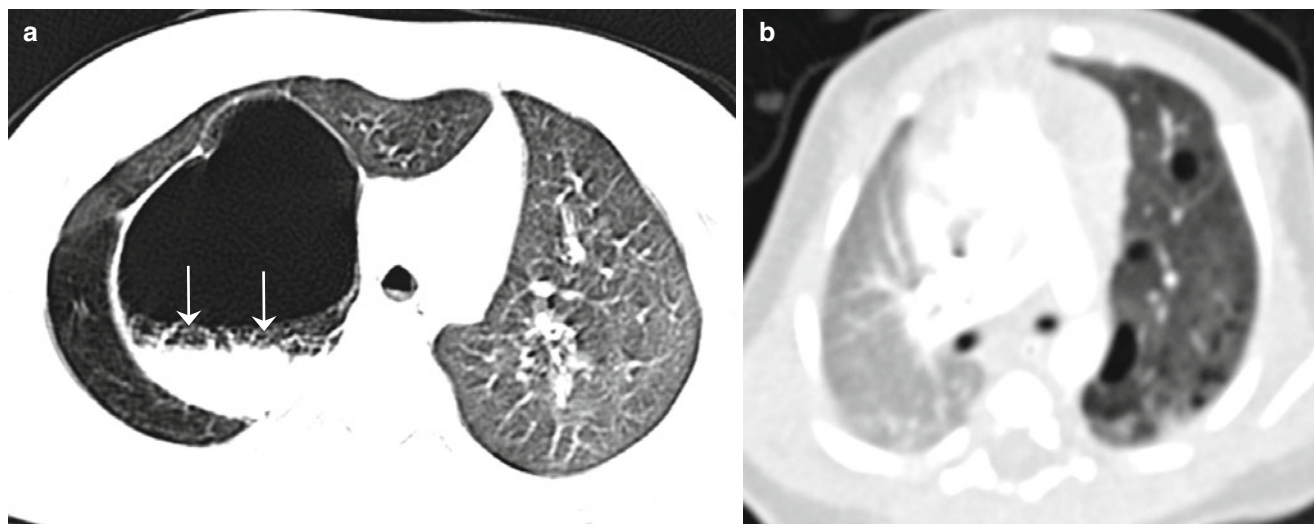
(a, b) Congenital pulmonary airway malformation. Axial CT image shows a large thick-walled cyst with an air–fluid level (*arrows*) in the right lung that was proven as an infected congenital pulmonary
